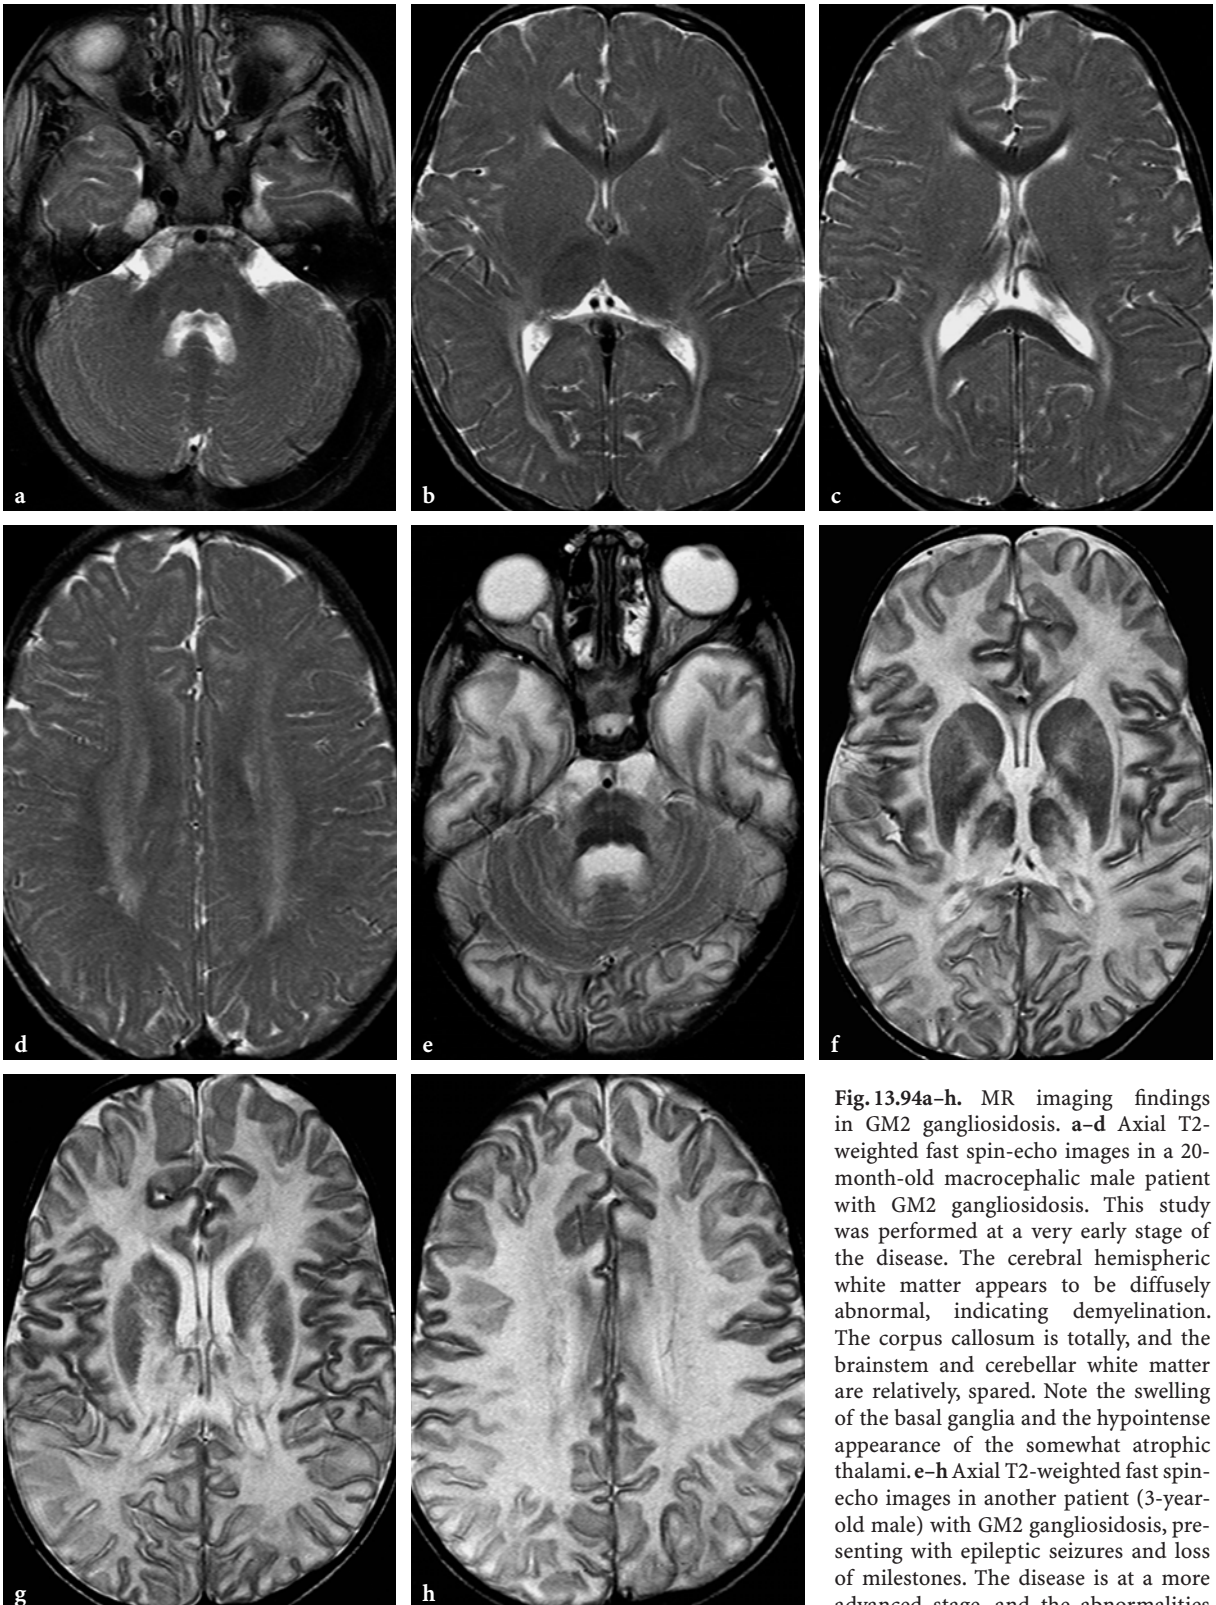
MR imaging findings in GM2 gangliosidosis. a-d Axial T2-weighted fast spin-echo images in a 20-month-old macrocephalic male patient with GM2 gangliosidosis. This study was performed at a very early stage of the disease. The cerebral hemispheric white matter appears to be diffusely abnormal, indicating demyelination. The corpus callosum is totally, and the brainstem and cerebellar white matter are relatively, spared. Note the swelling of the basal ganglia and the hypointense appearance of the somewhat atrophic thalami. e-h Axial T2-weighted fast spin-echo images in another patient (3-year-old male) with GM2 gangliosidosis, presenting with epileptic seizures and loss of milestones. The disease is at a more advanced stage, and the abnormalities are more prominent and extensive. The
